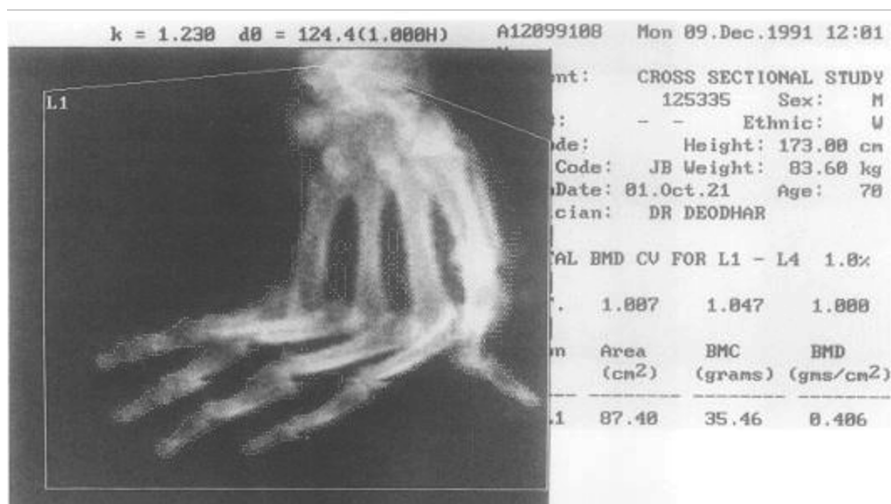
Hand bone densitometry by dual-energy X-ray absorptiometry in a patient with severe hand deformities due to rheumatoid arthritis. Patients with rheumatoid arthritis have lower hand bone mineral content (BMC) compared to age- and sex-matched controls. Because the hand surface area can change due to progressive hand deformities, BMC (rather than bone mineral density [BMD], which depends upon the area) should be monitored. BMC is independent of surface area. Reproduced with permission from Deodhar et al [12] ©BMJ.
